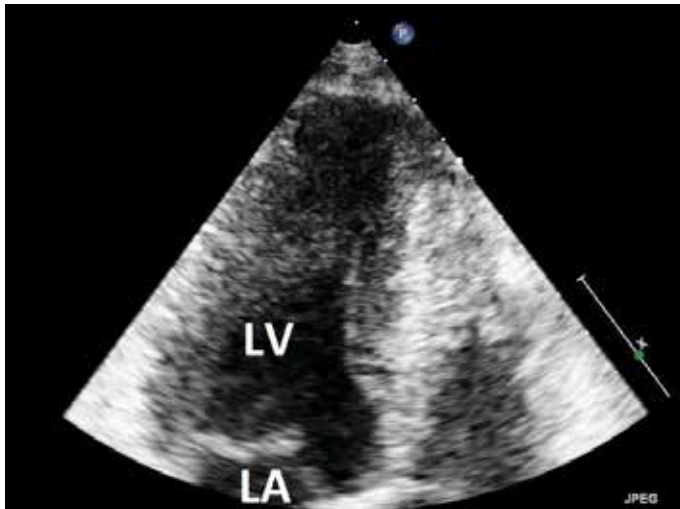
Apical hypertrophic cardiomyopathy visualization with two-dimensional transthoracic echocardiography
